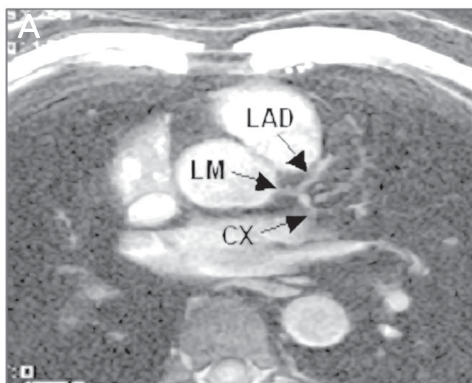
Magnetic resonance image of a 43-year-old male patient. A, View of the left main (LM), left anterior descending (LAD) and circumflex (CX) arteries. B, A cross-sectional view of the LAD with a clearly positive remodeling (arrow) between 1 and 5 h (total vessel area = 37 mm<sup>2</sup>).
